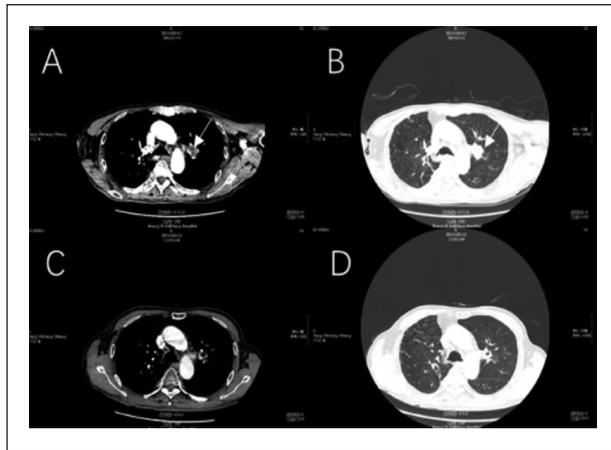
CT findings of typical NSCLC before and after treatment.
